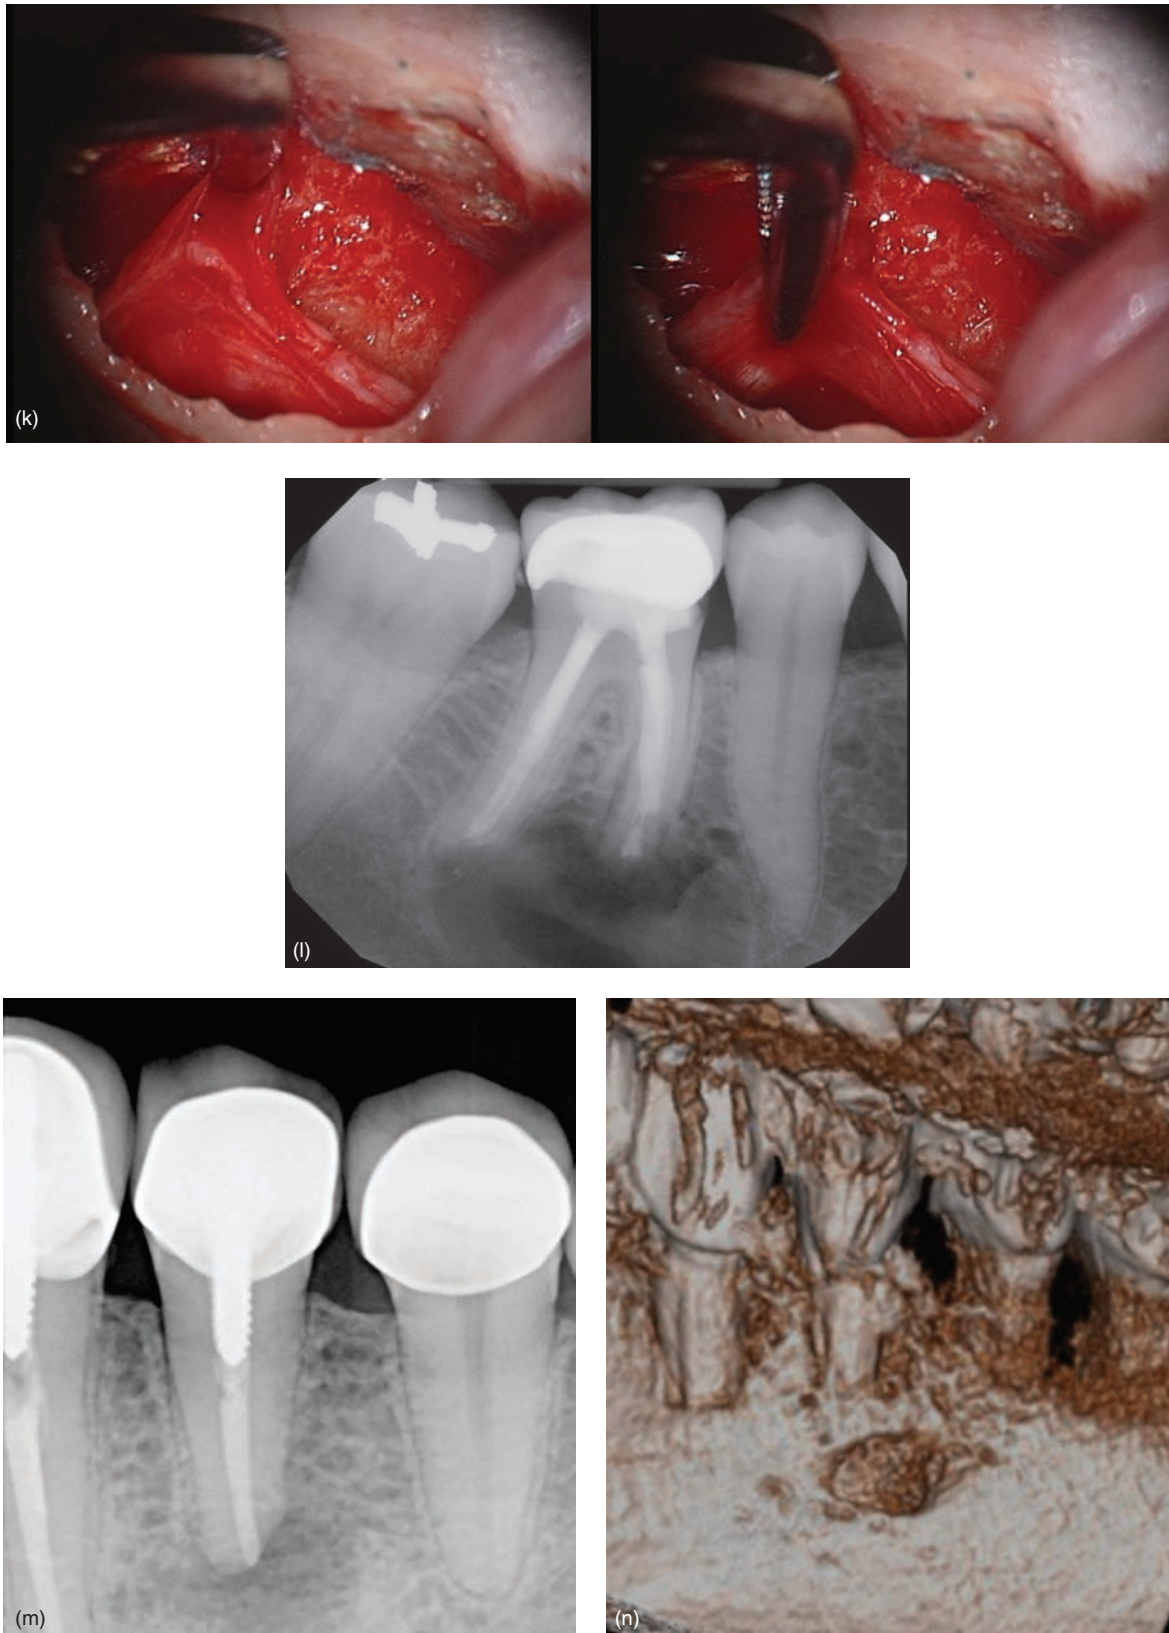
(Continued) (k) Surgical pictures showing the extent of lesion and exposed mandibular nerve. (l) Postsurgical radiograph showing resected mesial and distal roots with root end fillings. (m) Periapical radiograph showing the mandibular premolar with apical radiolucency. The tooth was previously treated and restored with a well-fitted PFM crown and post. (n) and (o) CBCT images showing the close proximity of the mental nerve to the root end. Intentional replantation was chosen. (p) Postreplantation radiograph showing root end resection with root end filling.
